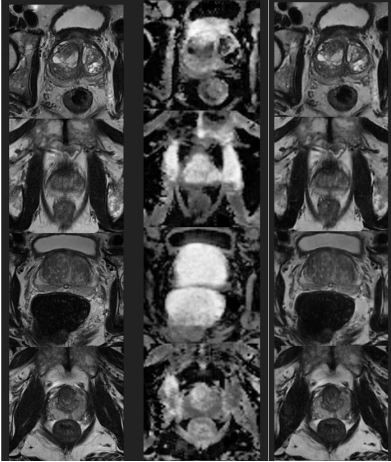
Preliminary DualGAN: T2 to ADC to T2 results: From left to right, one can visualize a patient’s scan in T2-weighted format transformed to ADC and then back to T2-weighted.
